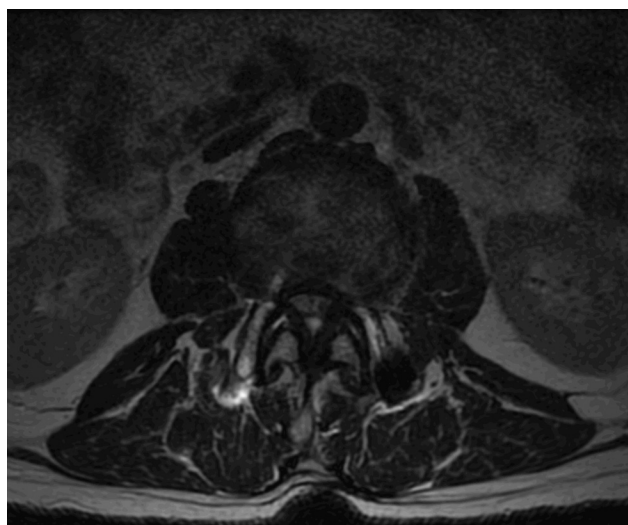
Axial T2-weighted image of the lumbar spine.
